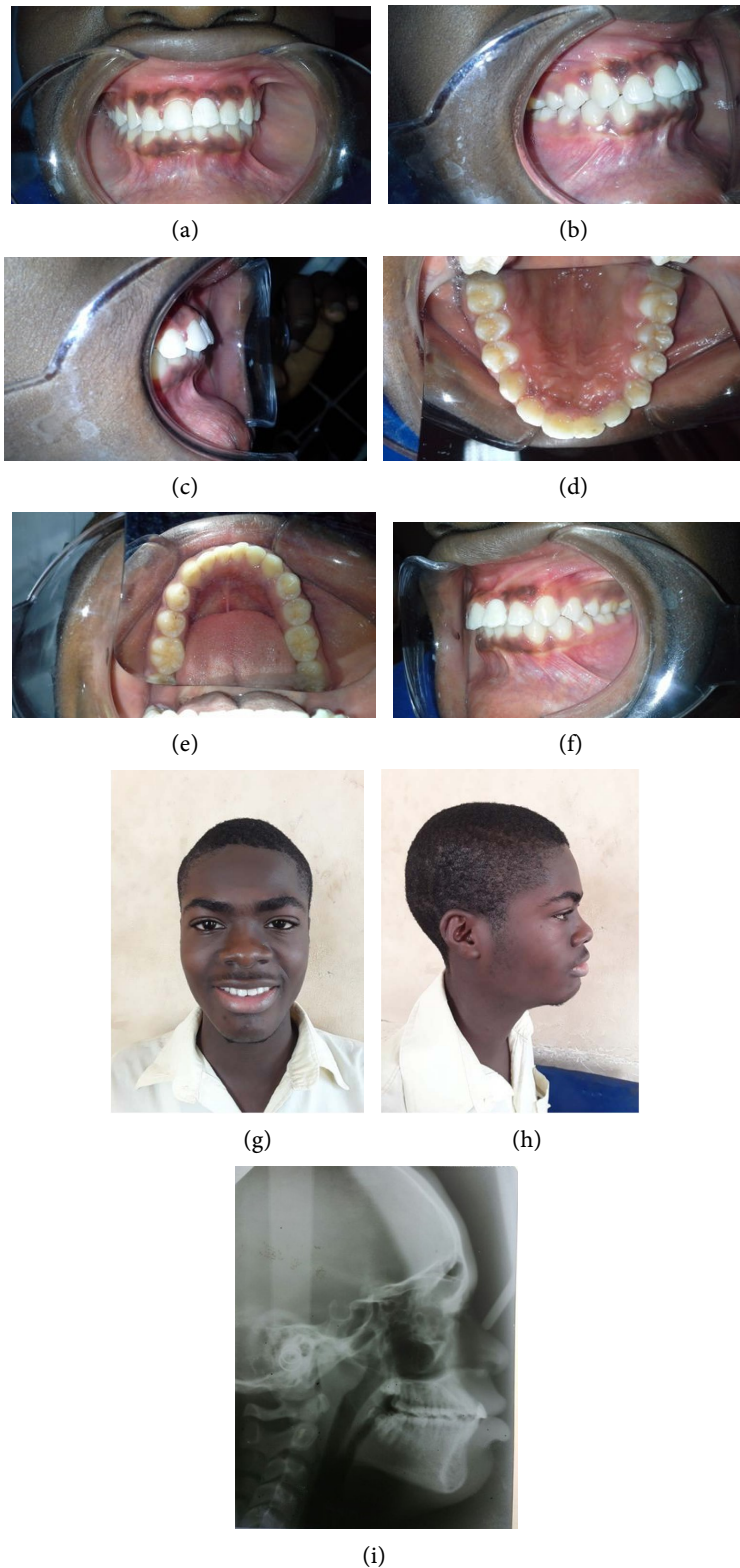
(a) Post-treatment intra oral frontal photograph; (b) Post-treatment Right buccal Occlusion; (c) Post-treatment overjet; (d) Post-treatment upper occlusal photograph; (e) Post-treatment Lower Occlusal photograph; (f) Post-treatment Left buccal occlusion; (g) Post-treatment extra oral frontal photograph; (h) Post-treatment extra oral profile photograph; (i) Post-treatment cephalometric X-ray.
